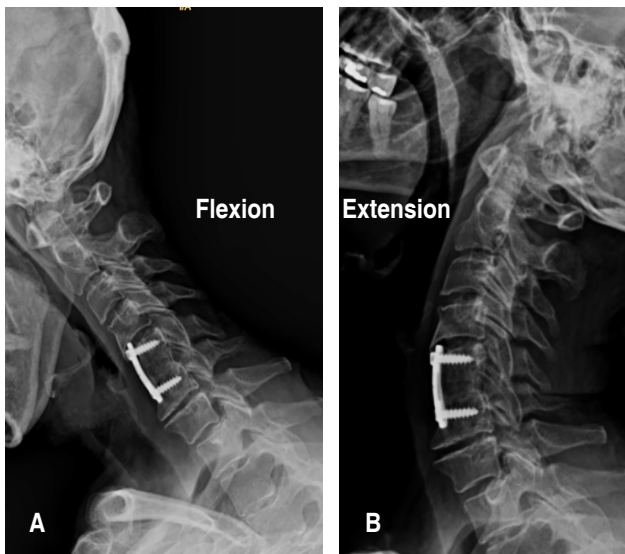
Preoperative dynamic cervical radiographs of case 1. A) Flexion. B) Extension. Anterior cervical arthrodesis at C5-C6 with plate and autologous bone graft (20-year evolution) showing adequate consolidation. Adjacent segment disease is evident at C4-C5, with disc space compromise and anterior plate invasion into the superior disc, findings that prompted hardware removal and new fusion.
